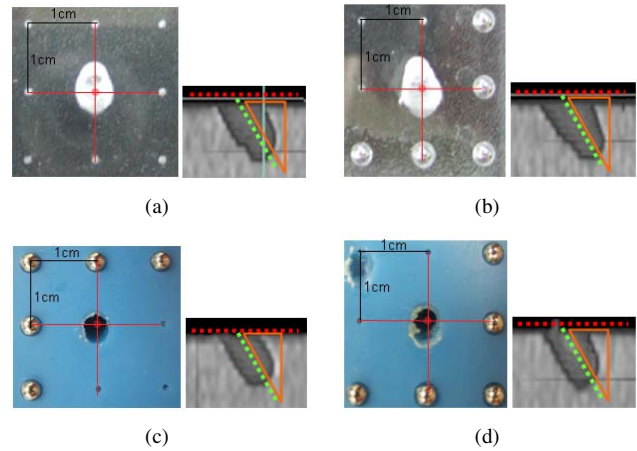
Experimental Result of high-speed drilling with the CoRASS (Left images are upper views taken by camera, right images are CT-scan images showing the cross-section) (a) Acryl, hole 1 (b) Acryl, hole 2 (c) Engineering plastic, hole 1 (d) Engineering plastic, hole 2.
